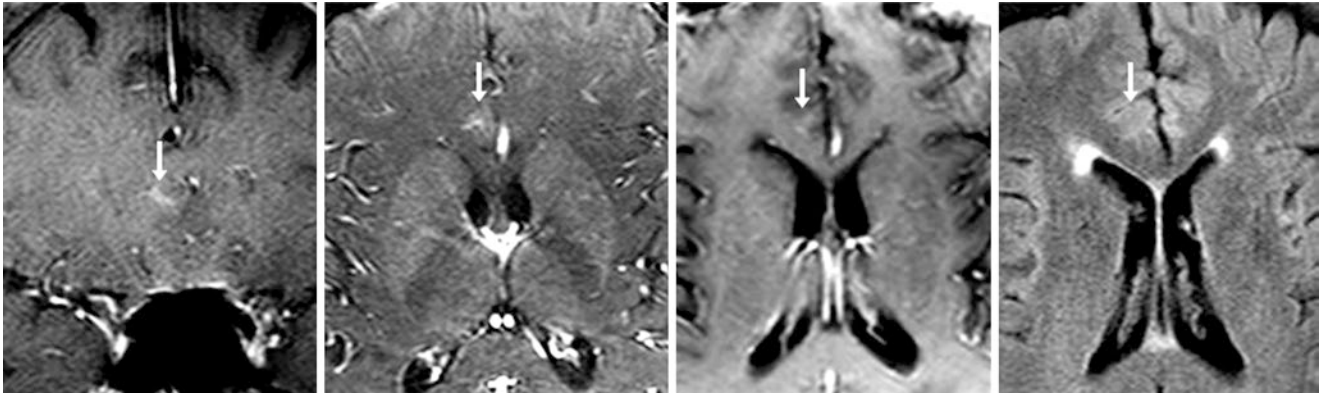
A 69 year old who had visual deficits underwent an otherwise negative 3T MRI that demonstrated a small, faint focus of enhancement (*arrows*) within the right cingulate gyrus on postcontrast coronal
